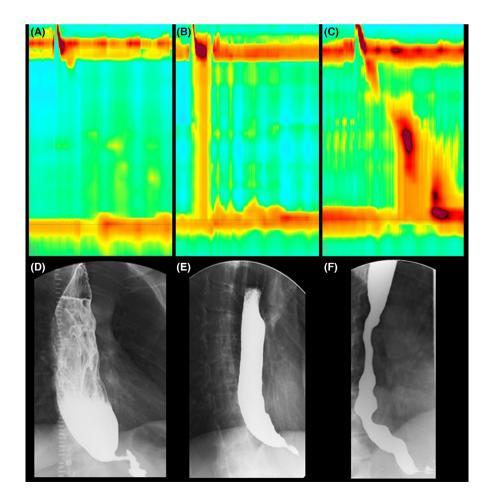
High-resolution manometry and Barium X-Ray features of Achalasia subtypes. All display impaired lower esophageal sphincter (LES) relaxation, usually characterized by a "bird-beak" narrowing at the LES radiographically (C, D). In type I, there is no significant pressure activity within the esophageal body in response to swallows, and the barium study typically reveals marked esophageal dilation (A, D). In type II, swallows result in panesophageal pressurization and the degree of esophageal dilation is less marked (B, E). In type III there are simultaneous contractions in the esophageal body that often produces a corkscrew effect on barium X-Ray (C, F).
